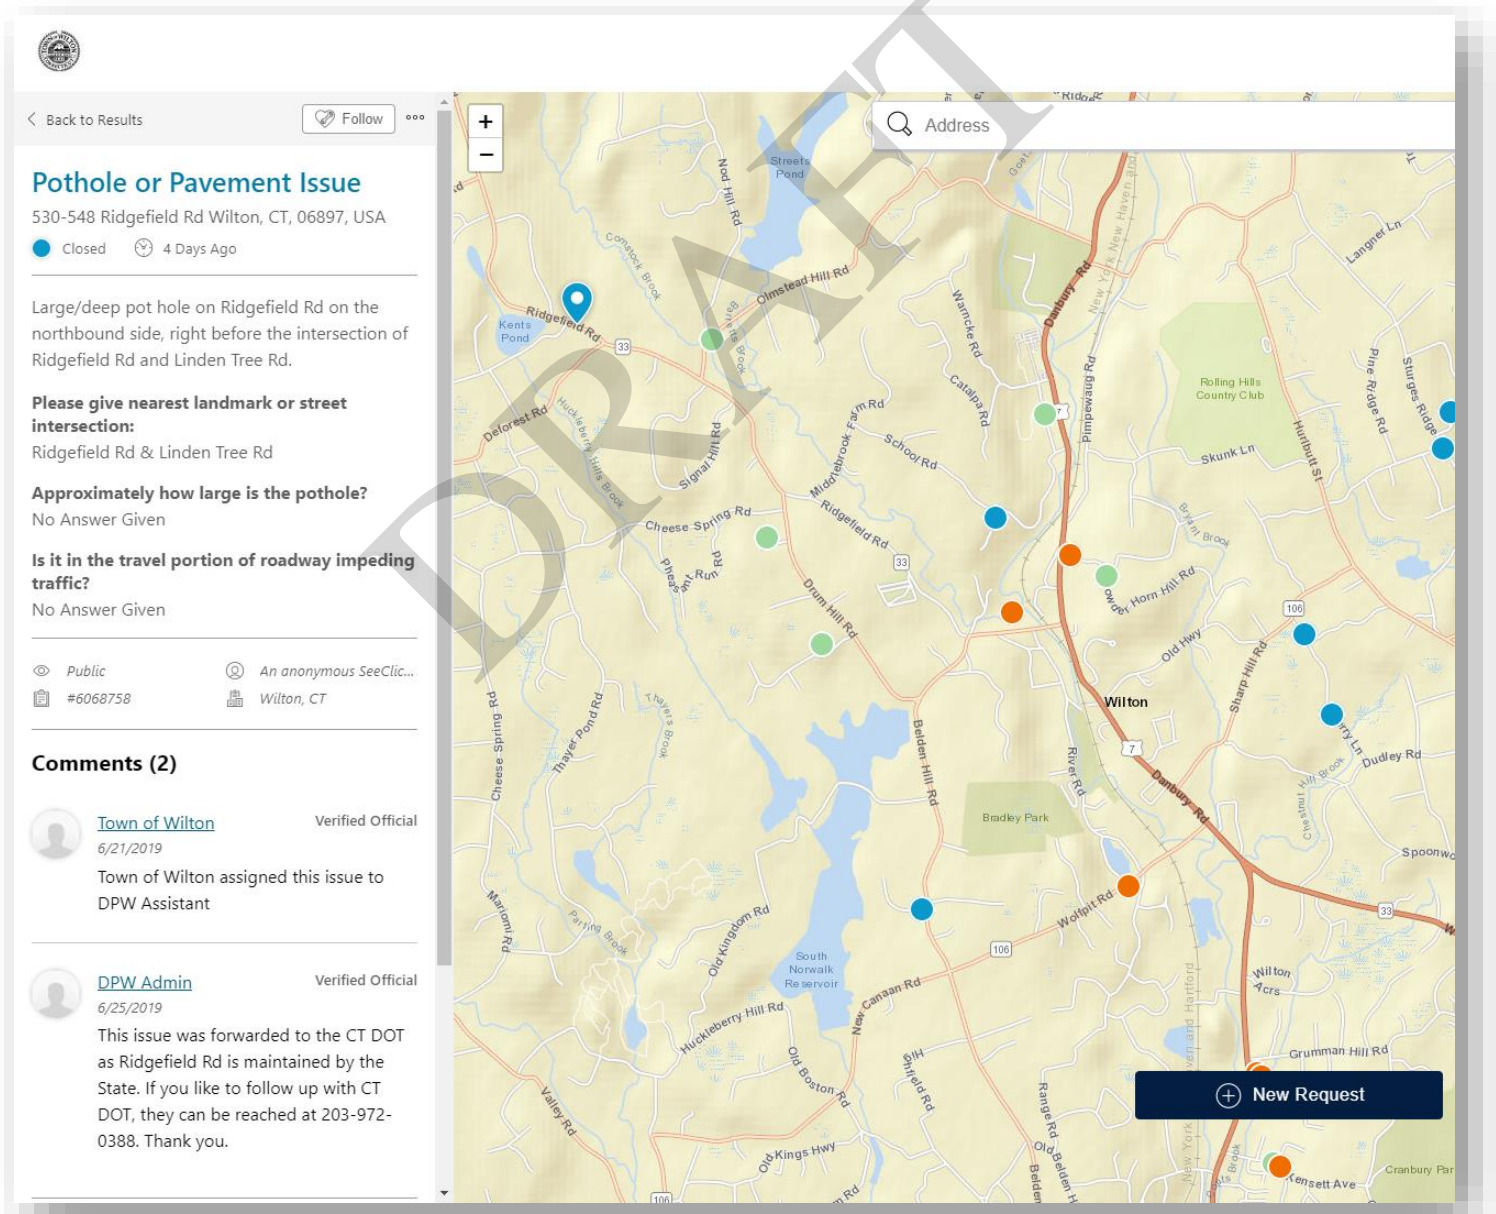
See Click Fix request for pothole repair in Wilton, CT
